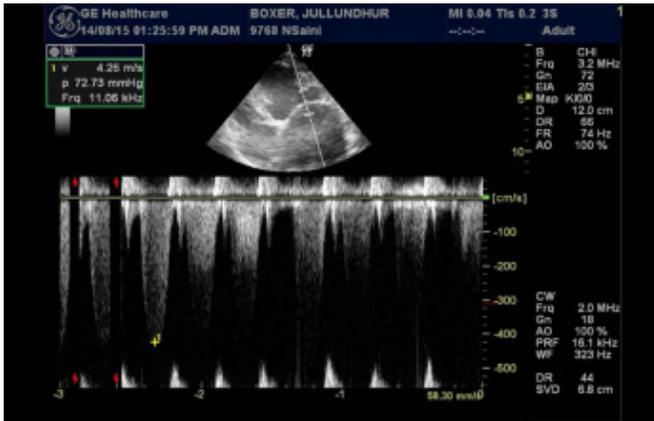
Left apical four-chamber view with continuous-wave doppler at mitral valve measuring the mitral flow regurgitant velocity of 4.26 m/sec.
